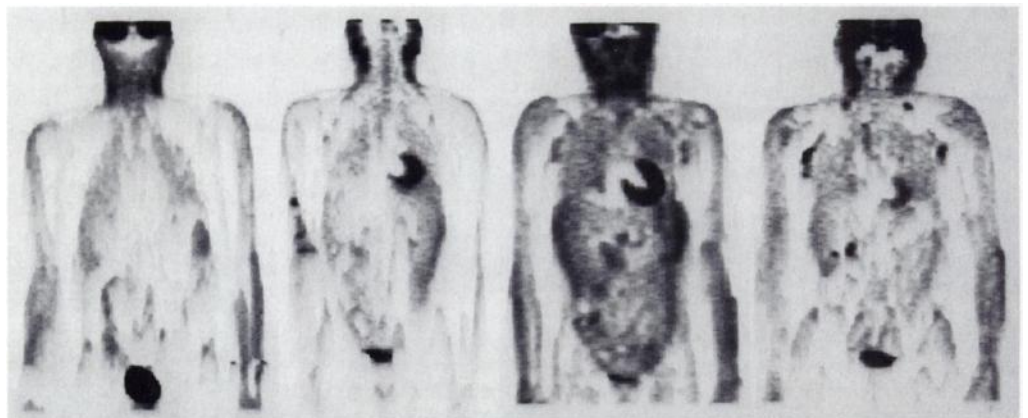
Variable uptake of FDG in lymph nodes of four of the 15 patients with PGL.
